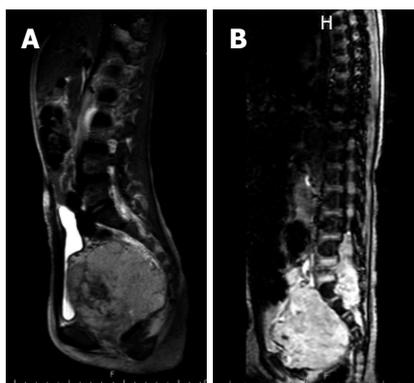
Magnetic resonance imaging T2: Providing a comparison between growth patterns. A: Pelvic RMS; B: MPNST. Although RMS is a locally advanced tumor, a thin surgical plane typically exists between the tumor and the adjacent bone when the MPNST involves the dural space and nerve root. RMS: Rhabdomyosarcoma; MPNST: Malignant peripheral nerve sheath tumor.
